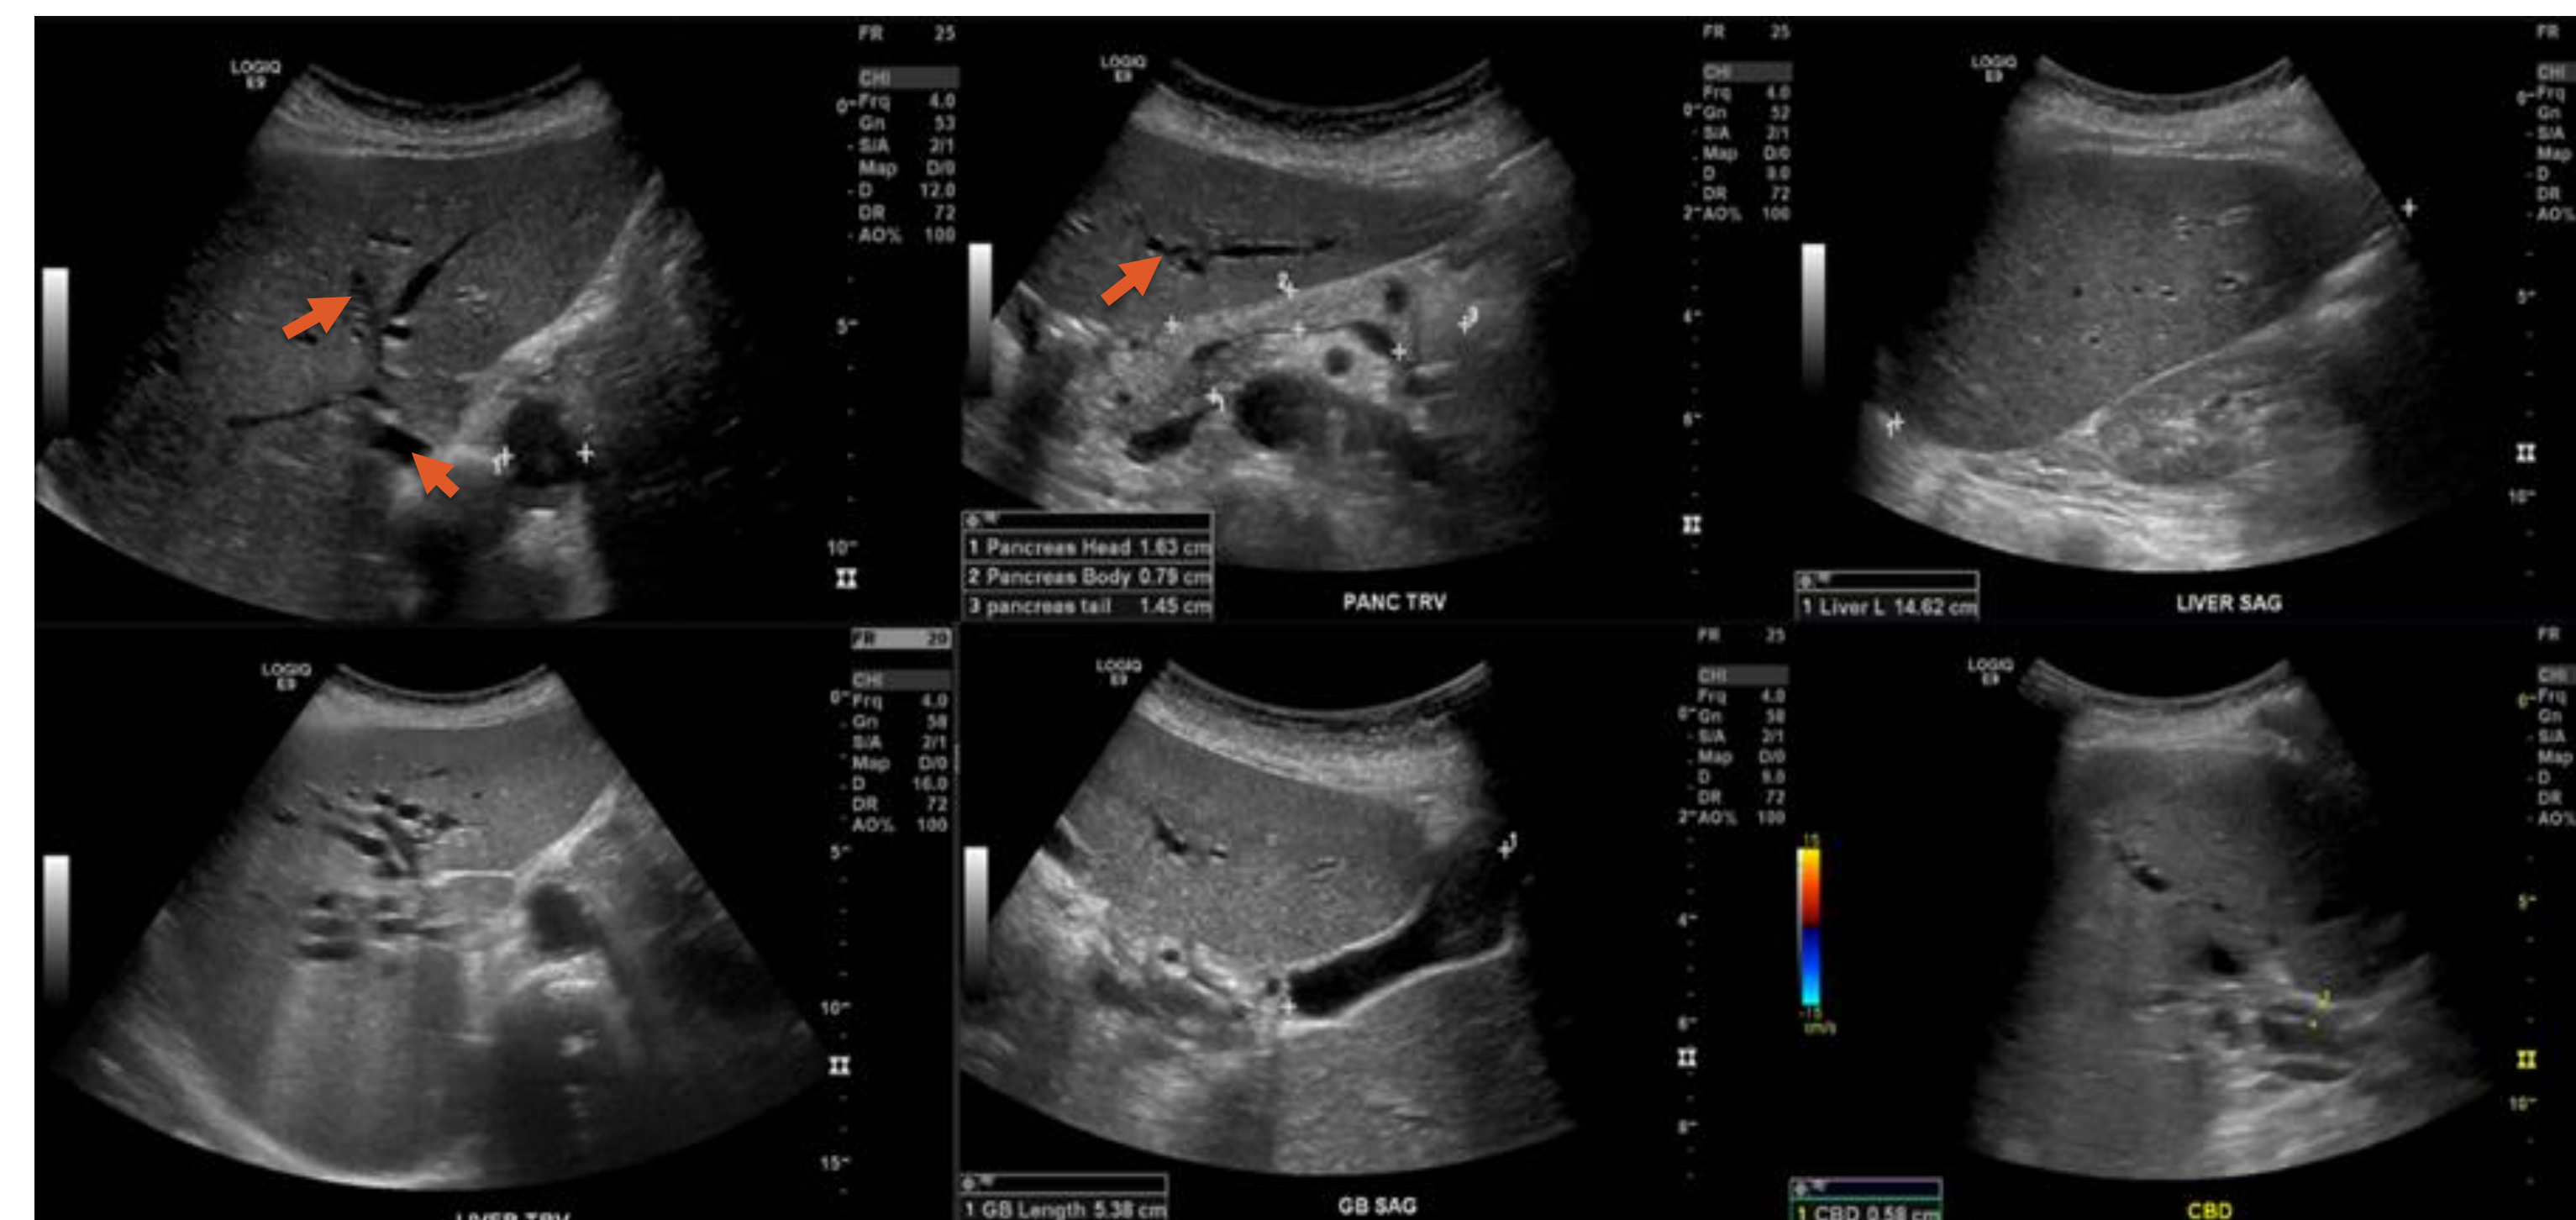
Abdominal ultrasound with findings of intrahepatic biliary ductal dilation (some indicated with arrows) without gallstones, hepatomegaly, or abnormalities in gallbladder, common bile duct, or pancreas.
